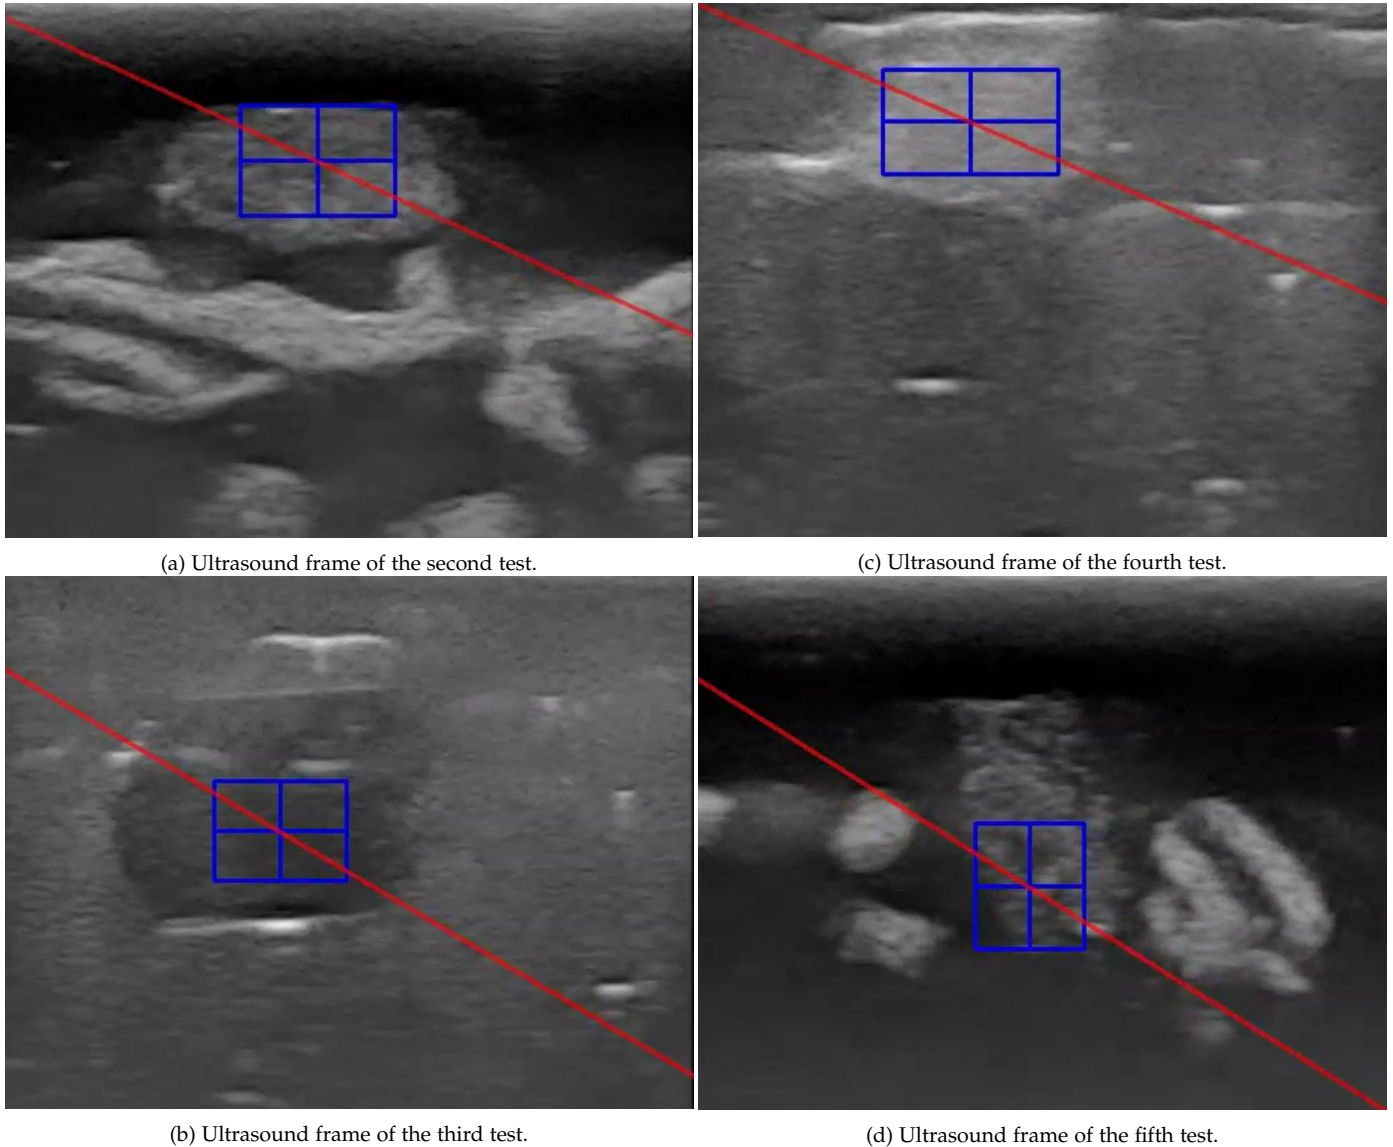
Ultrasound frame for the tracking tests. The blue box is the ROI where the cross indicates the CoM. The red line indicates the needle path. These tumors are used for the Mean Shift and CamShift tests.
